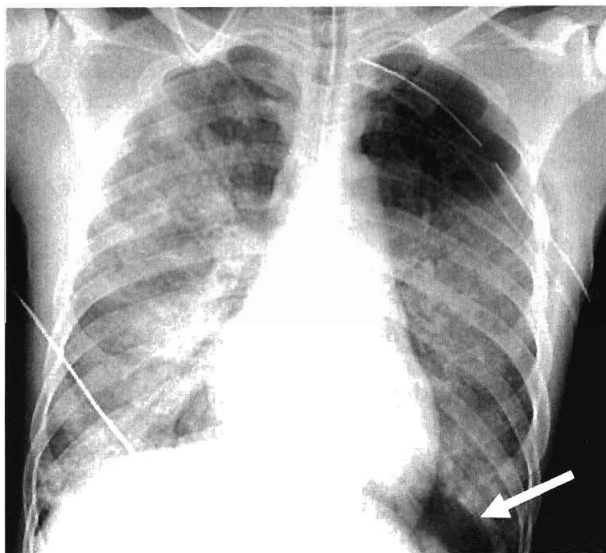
A 22-year-old man with clinical sepsis developed hypoxia 2 days after admission. An anteroposterior chest radiograph shows diffuse lung opacity with normal heart size, consistent with noncardiogenic pulmonary edema. Also note a pneumothorax in the left costophrenic angle (arrow).
